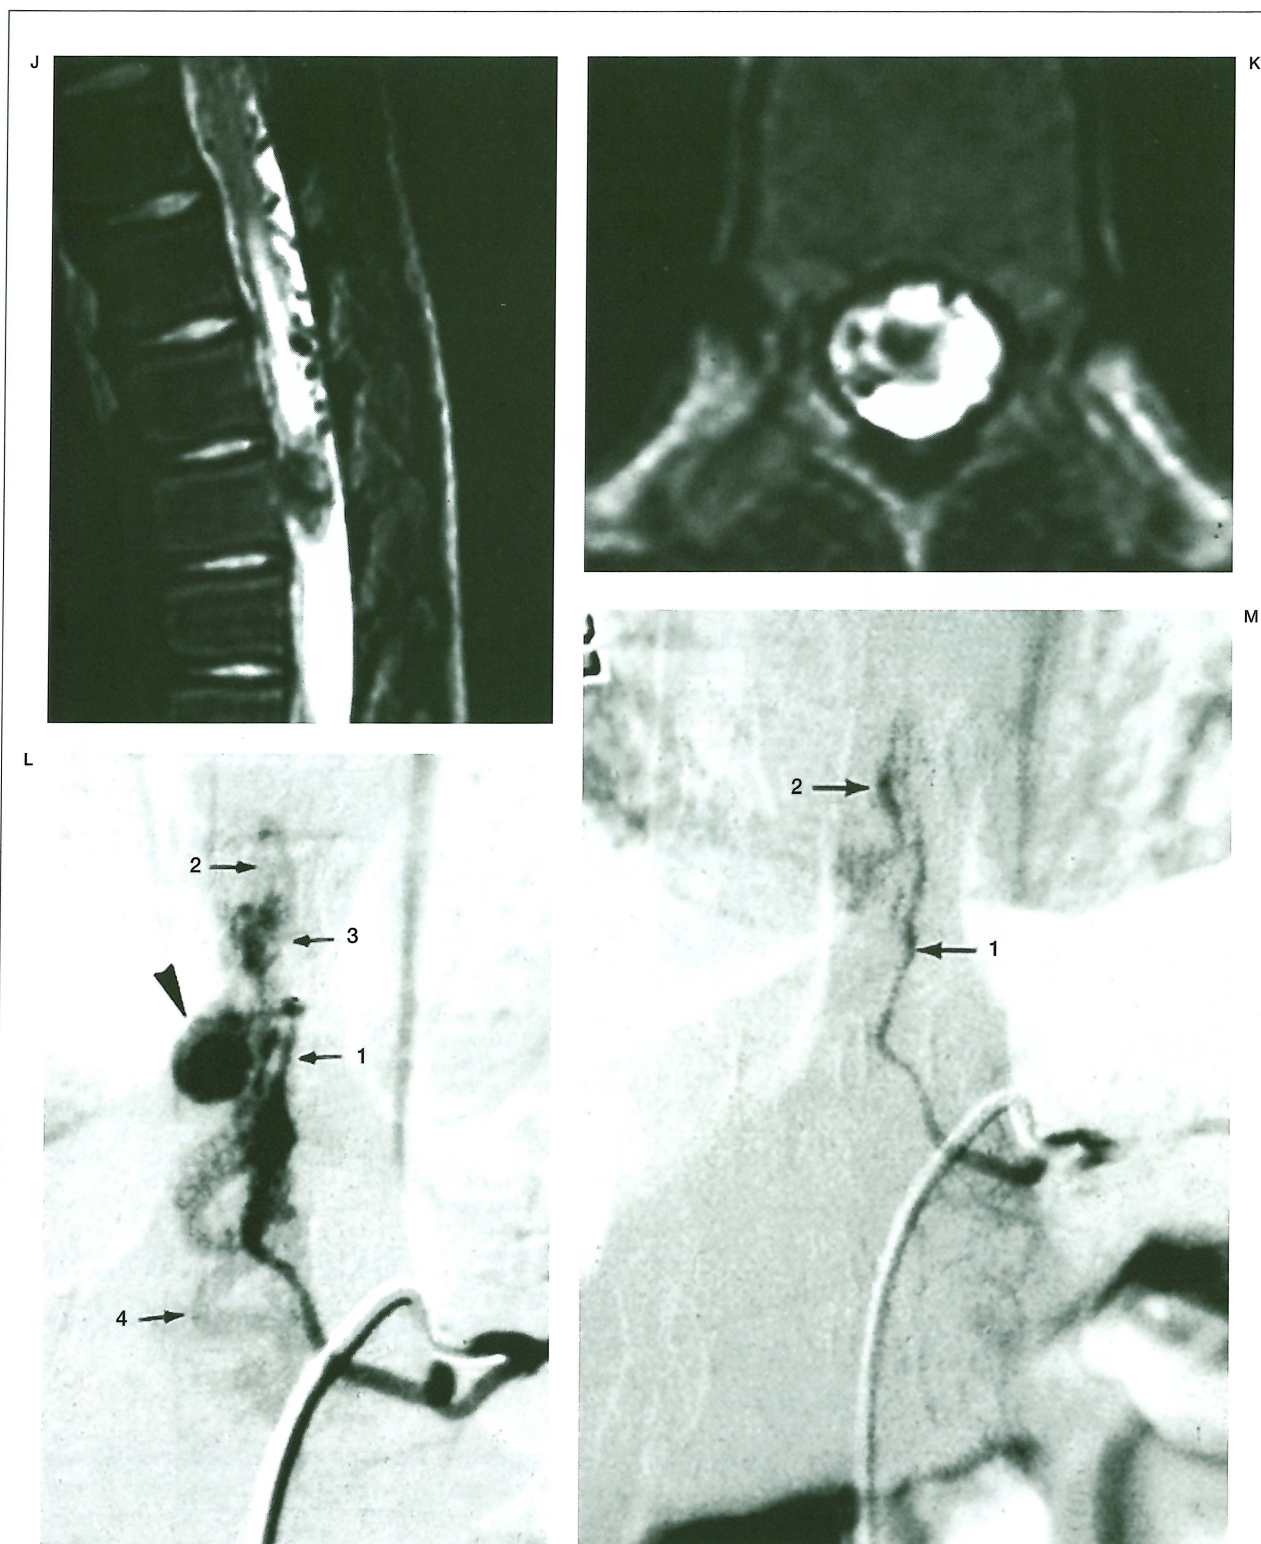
J-M) T8-9 intramedullary AVM with an aneurysm. A 16-year-old male presented with acute onset of paraparesis with grade 2-3 muscle power for 20 days. (J) Sagittal and (K) axial T2-weighted MR images show the intramedullary signal void at the T8-9 level. (L) Selective injection of the left T10 intercostal artery in A-P view shows an AVM (3) supplied by the posterior spinal artery (2) of the posterior radiculo-medullary artery (1) with caudal venous drainage (4). Note the aneurysmal dilation (arrowhead). (M) Angiogram of the left T10 intercostal artery after embolisation with Embosphere (500-700 µm) shows complete obliteration of the nidus, aneurysm and the draining vein, with preservation of the posterior spinal artery (2).
